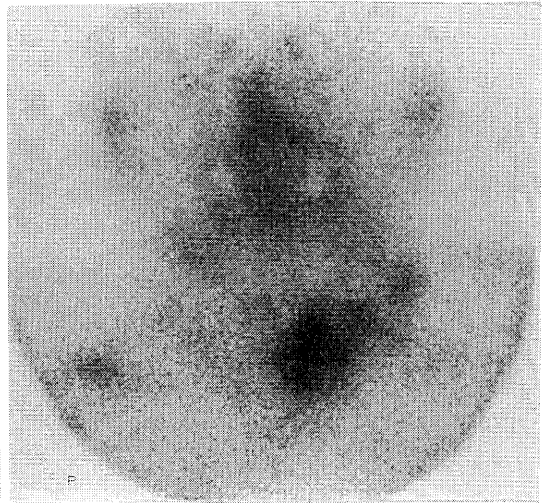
Tl201 scintigram obtained 20 minutes after 111 MBq of $^{201}\text{TlCl}$ intravenous injection. Abnormal radiothallium accumulations are seen in the left lower neck.
